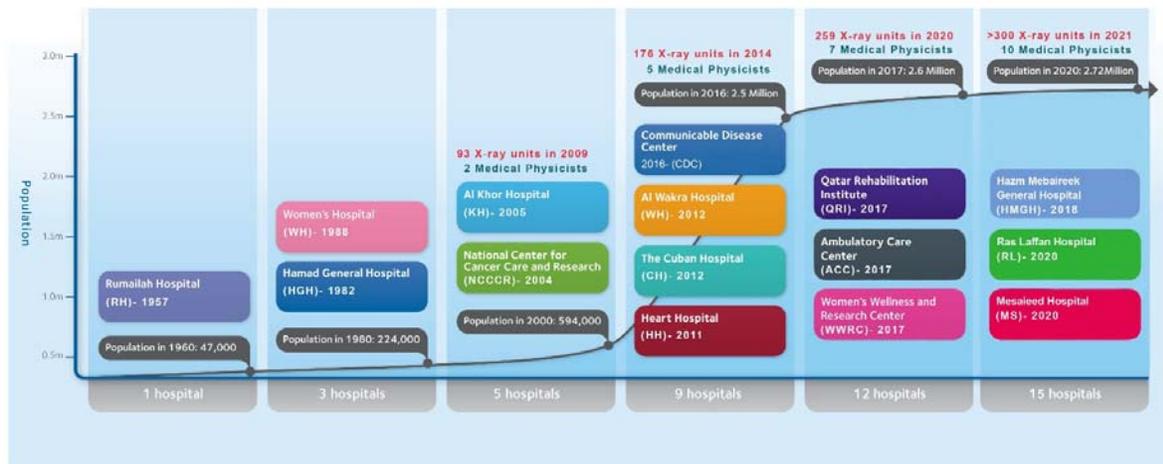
The timeline of the increase of number of hospitals under HMC (including the number of X-ray units and Medical Physicists) with the increase of population in Qatar from between 1957 and 2020.
